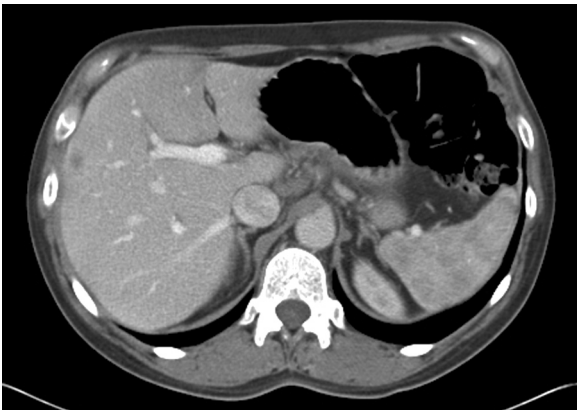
CT image 45 days approximately after initiation of chemotherapy, demonstrating almost a 50% reduction in size of liver metastasis, measuring 0.8 cm.
